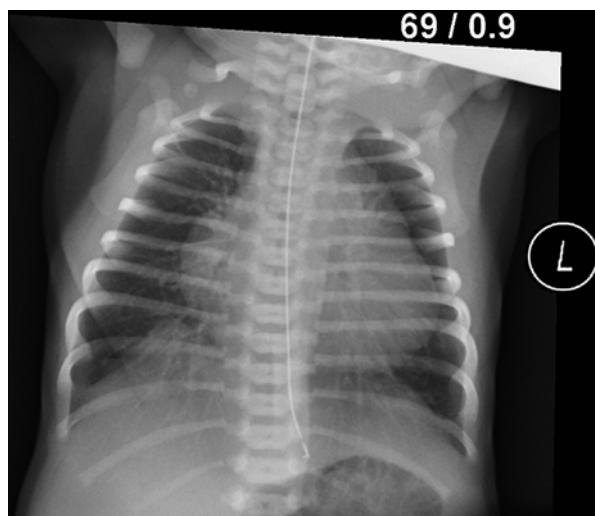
Chest x-ray showing a slightly enlarged cardiac shadow and streaky lung fields in case 1
